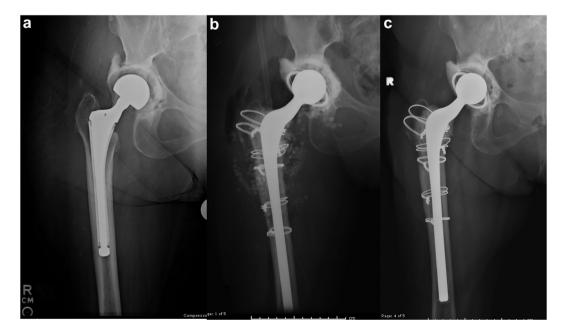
(a) AP radiograph of the right hip taken prior to first-stage revision total hip arthroplasty showing constrained liner. (b) AP radiograph of the right hip taken immediately following first-stage revision, showing a constrained liner cemented in place. (c) AP radiograph of the right hip taken at a 3-year follow-up. AP, anterior to posterior.
